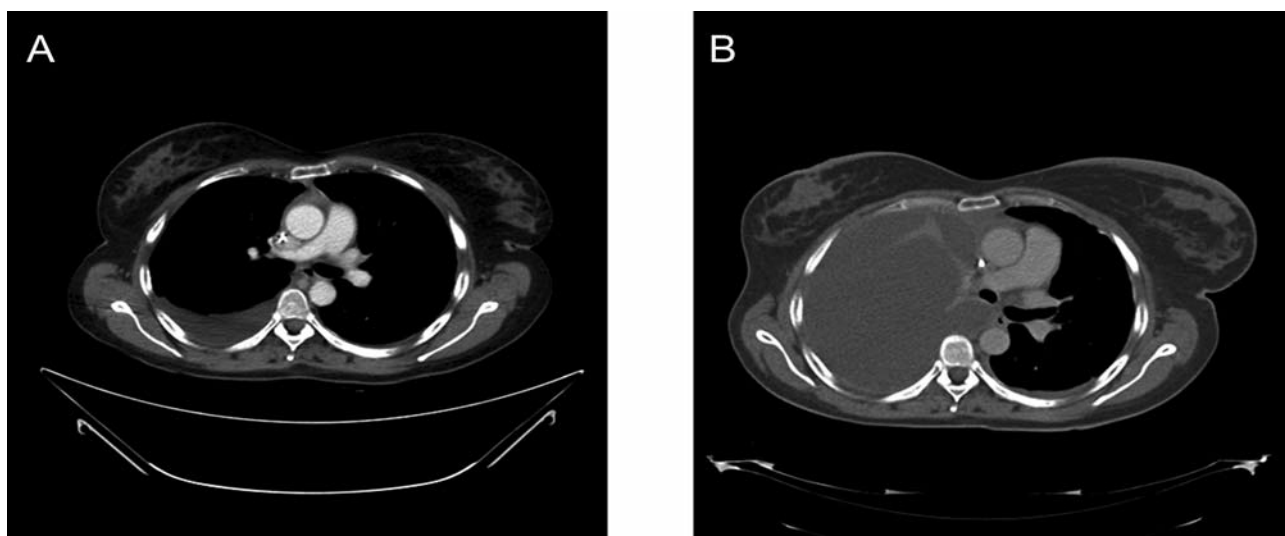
A: CT scan 2 weeks prior to vaccination, showing minimal pleural effusion in the right lung. B: CT scan 1 week after V4 showing progressive disease: increase of pleural effusion in the right lung and rise of pleural metastasis in the left lung.
